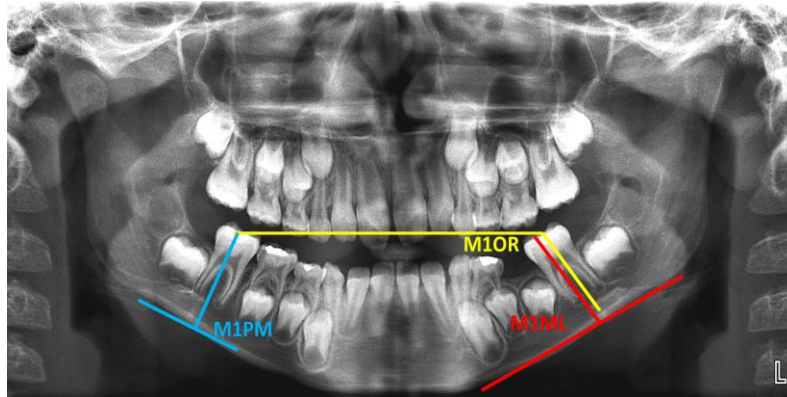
Panoramic X-ray measurements evaluating mesial first permanent molar inclination.
